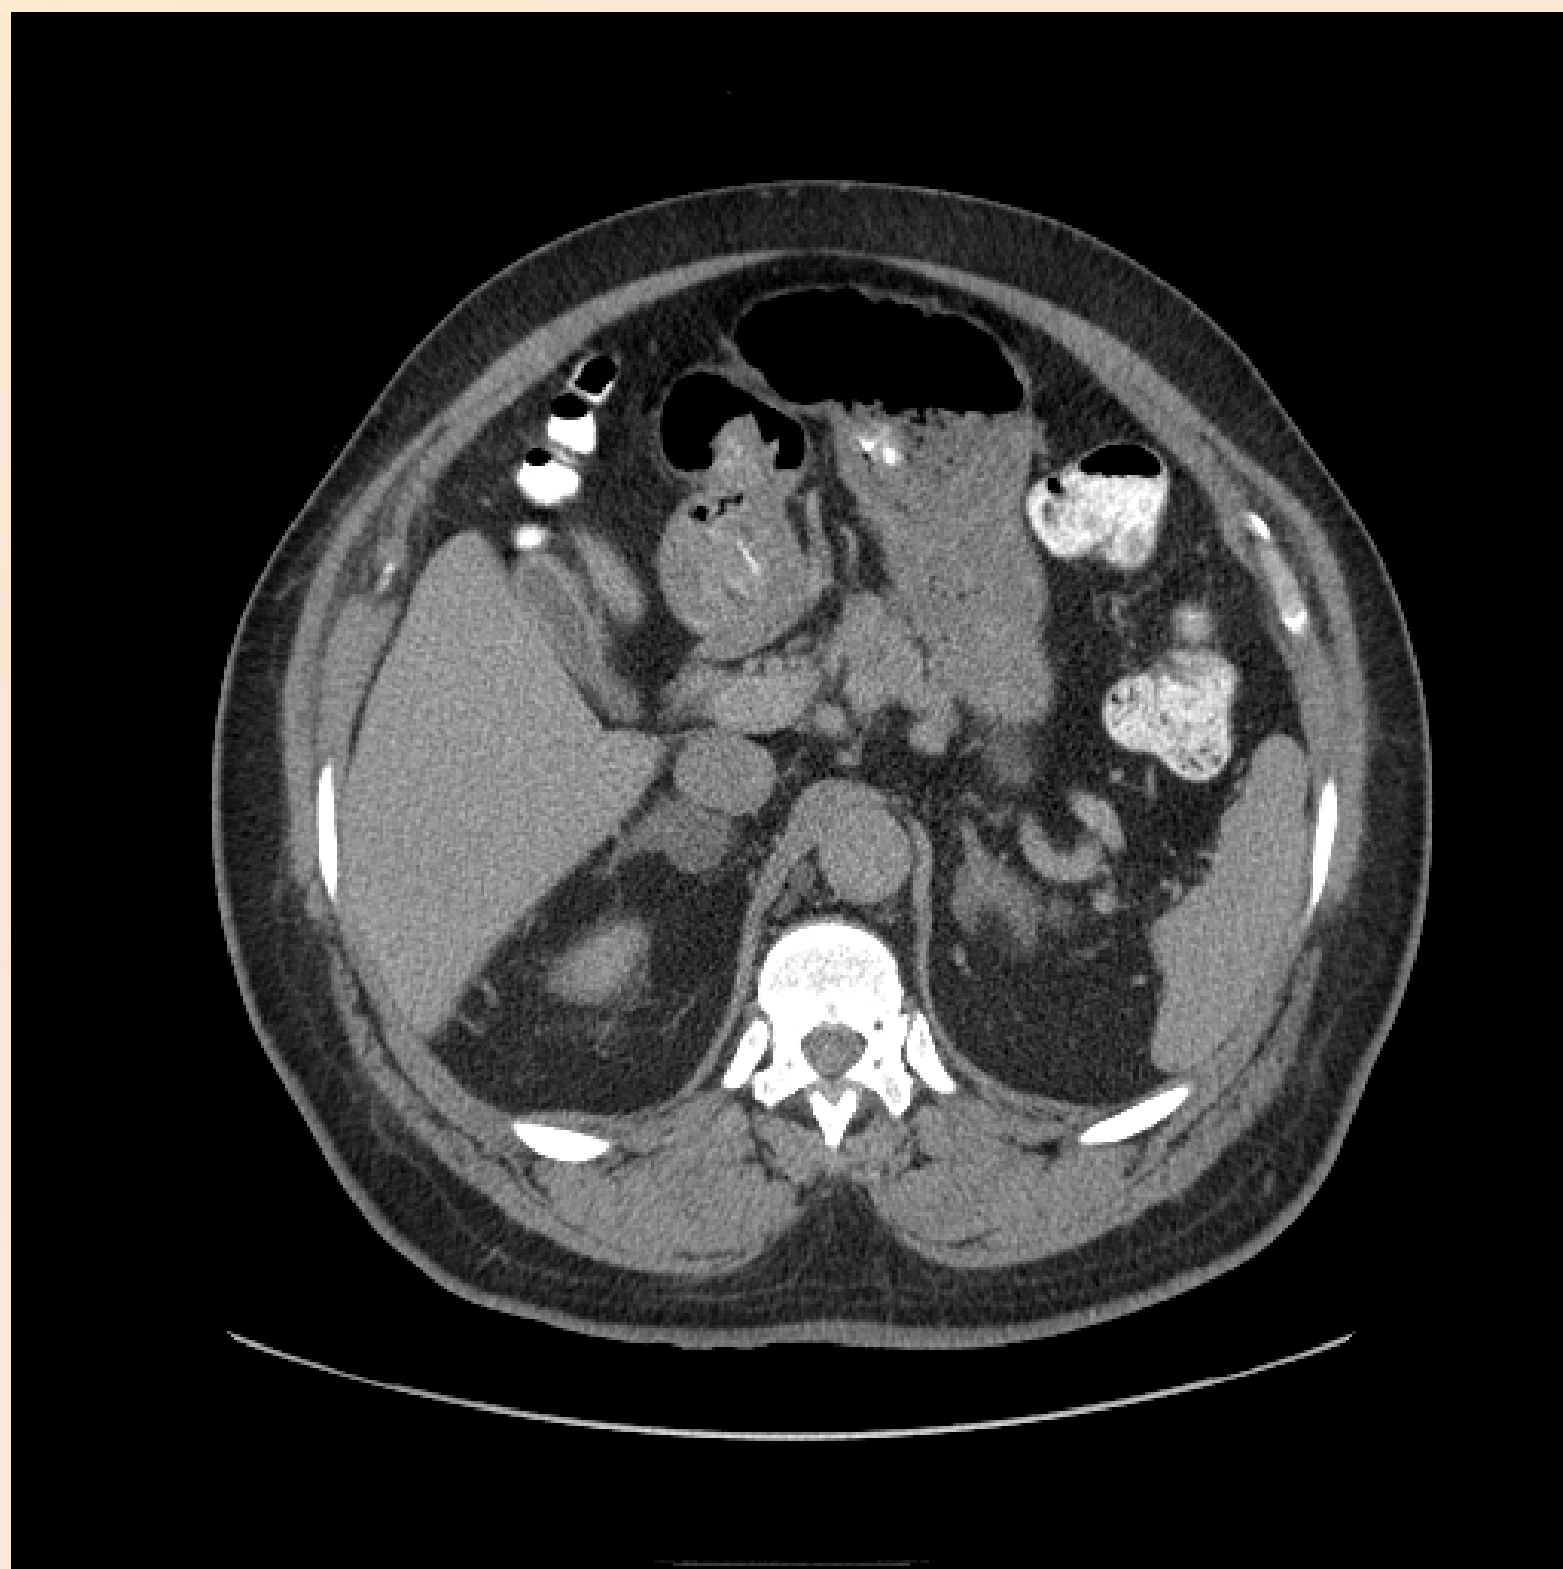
CT of Abdomen with contrast showing right adrenal nodular lesion and left adrenal limb thickening representing hyperplasia.
